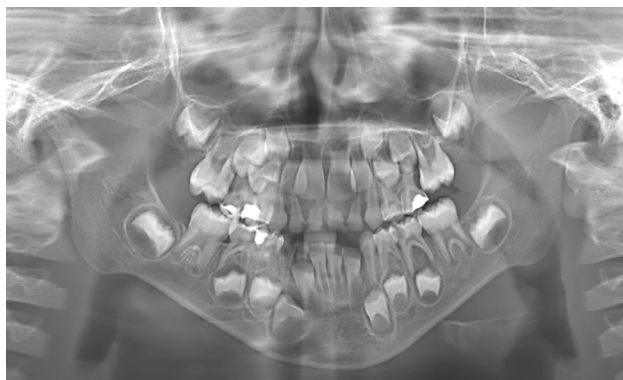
Panoramic radiograph obtained for diagnostic and treatment planning purposes. Carious involvement of the deciduous dentition is conspicuous.
